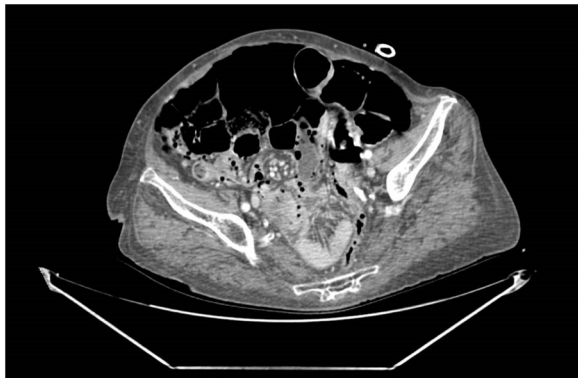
Abdominal CT scan: pneumoperitoneum and pneumatosis intestinalis.
